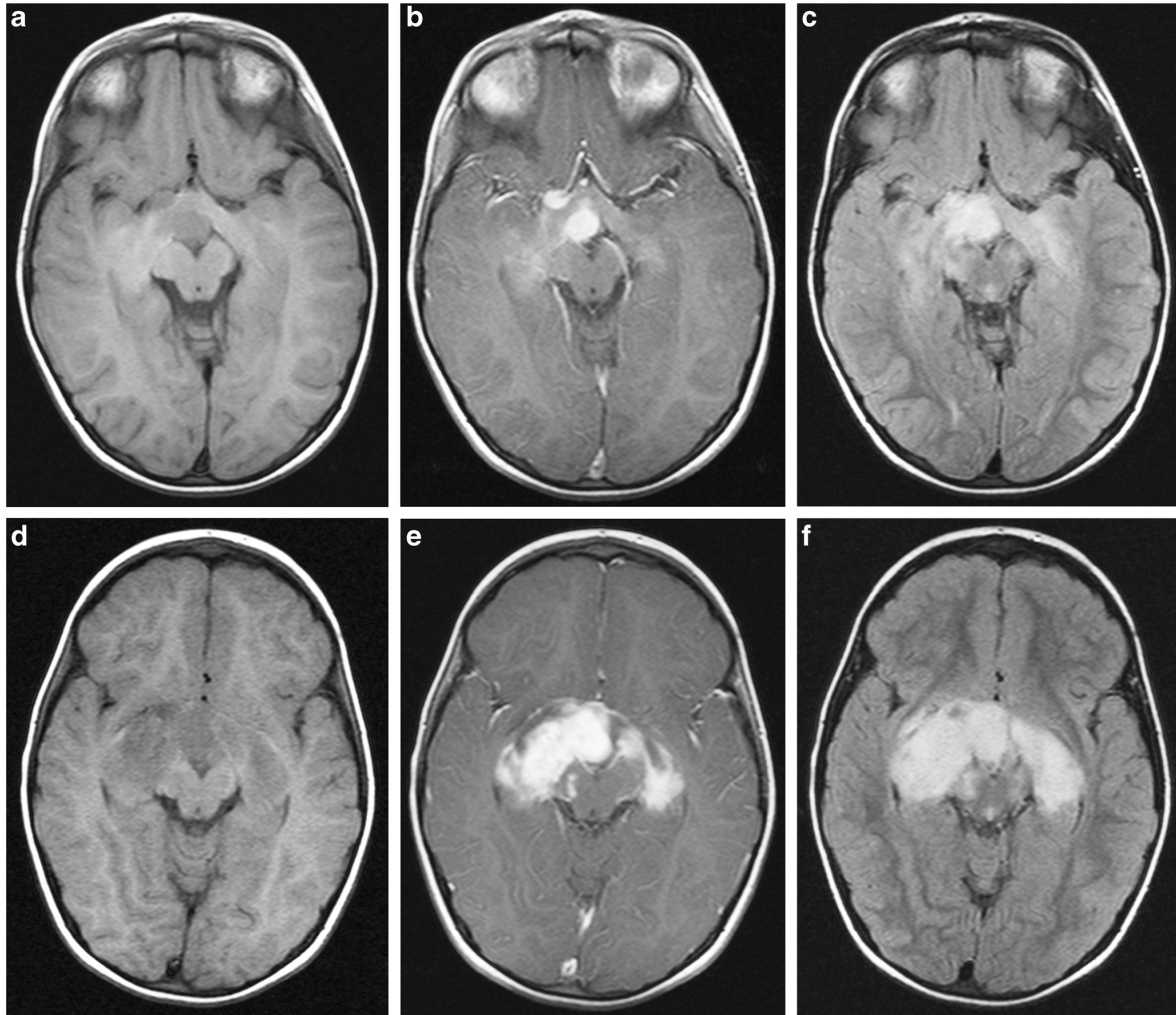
Example case. 3 year-old male undergoing routine 3-month interval follow-up of a sporadic isolated OPG diagnosed 2 years previously. Axial T1 weighted (A & D), post-contrast (B&E), and non-contrast fluid attenuated inversion recovery (FLAIR; C&F) images at the level of the midbrain are shown from two consecutive CEMR exams. The CEMR from baseline (A-C) showed stable disease, and ophthalmologic exam revealed stable visual testing abnormalities. The CEMR from 3 months later (D-F) showed increase in tumor size that was readily apparent on both the axial post-contrast T1 and FLAIR sequences, although visual testing abnormalities / exam
